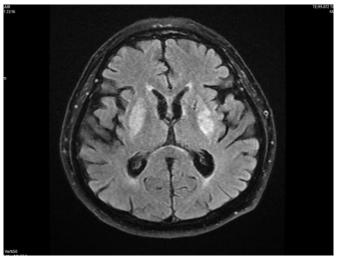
FLAIR image shows increased signal intensity in both basal ganglia lesions (white arrows indicate lesions).
